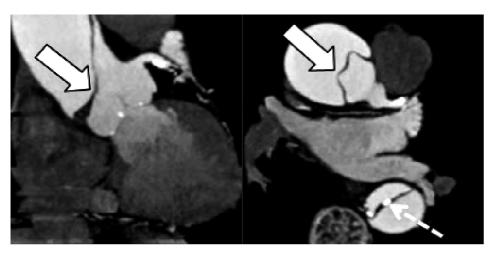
Aortic dissection Stanford type A of a 75-year-old woman with chest pain who underwent a 128-slice coronary CT angiography. Dissection flap (arrows) originating in the ascending thoracic aorta and extending throughout the aortic arch and descending thoracic aorta (dashed arrow).
